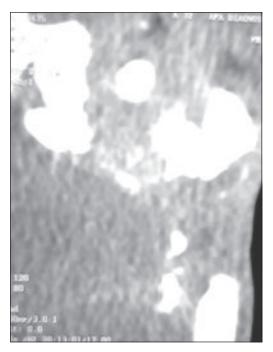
Axial cut of contrast enhanced computed tomography (CECT) showing mildly enhanced tumor involving occipital bone and mastoid air cells with destruction of bone.
